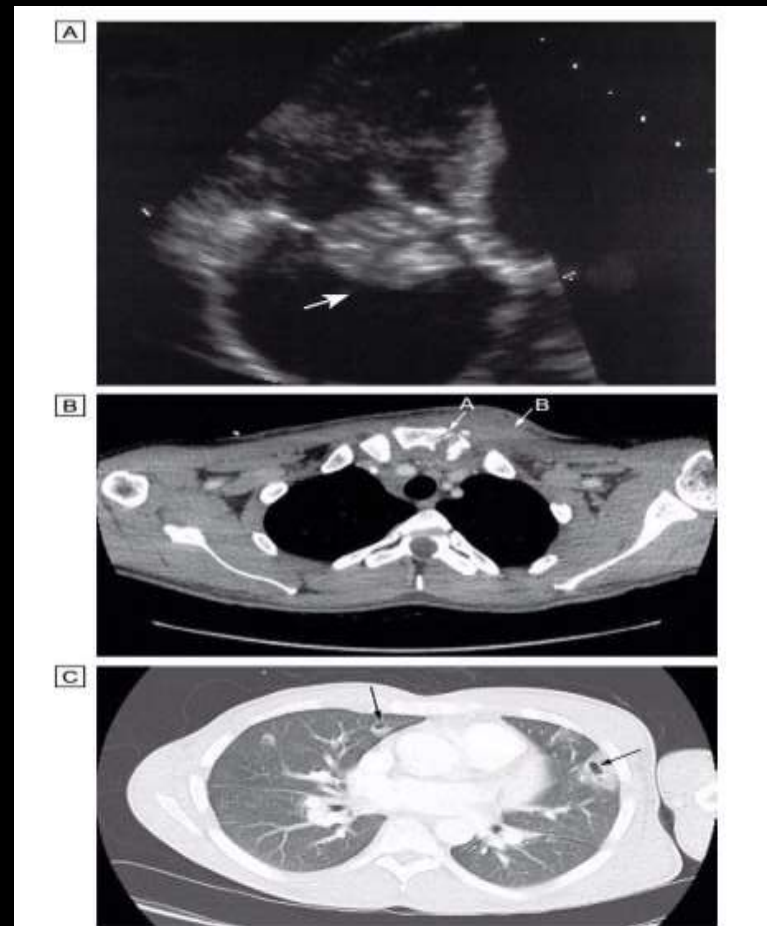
Causes of fever in the injection drug-user. [A] Endocarditis in an injection drug-user. Large vegetation on the tricuspid valve (arrow). [B] Septic arthritis of the left sternoclavicular joint (arrow A) (note the erosion of the bony surfaces at the sternoclavicular joint) with overlying soft tissue collection (arrow B). [C] CT of the thorax from an injection drug-user with haemoptysis, showing multiple embolic lesions with cavitation (arrows). The patient had *Staph. aureus* endocarditis of the tricuspid valve.
